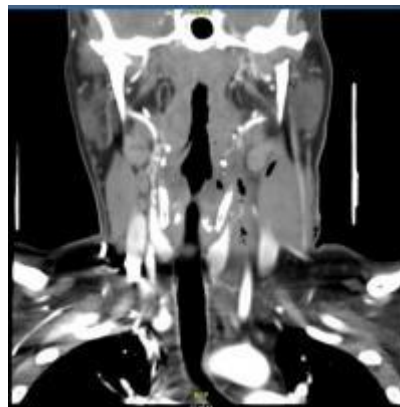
Coronal view CT scan neck - Soft tissue swelling with subcutaneous haematoma in neck along with subcutaneous emphysema involving pre-laryngeal, pre and para-tracheal space.
